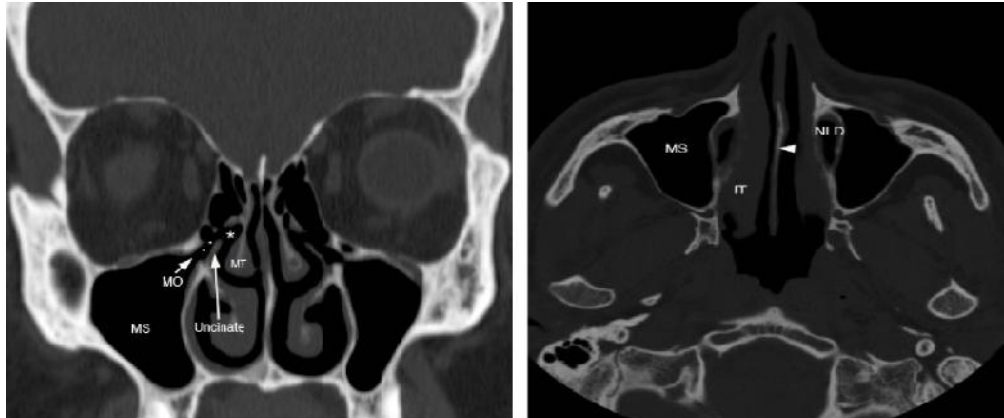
Coronal and Axial CT images showing maxillary sinus.
